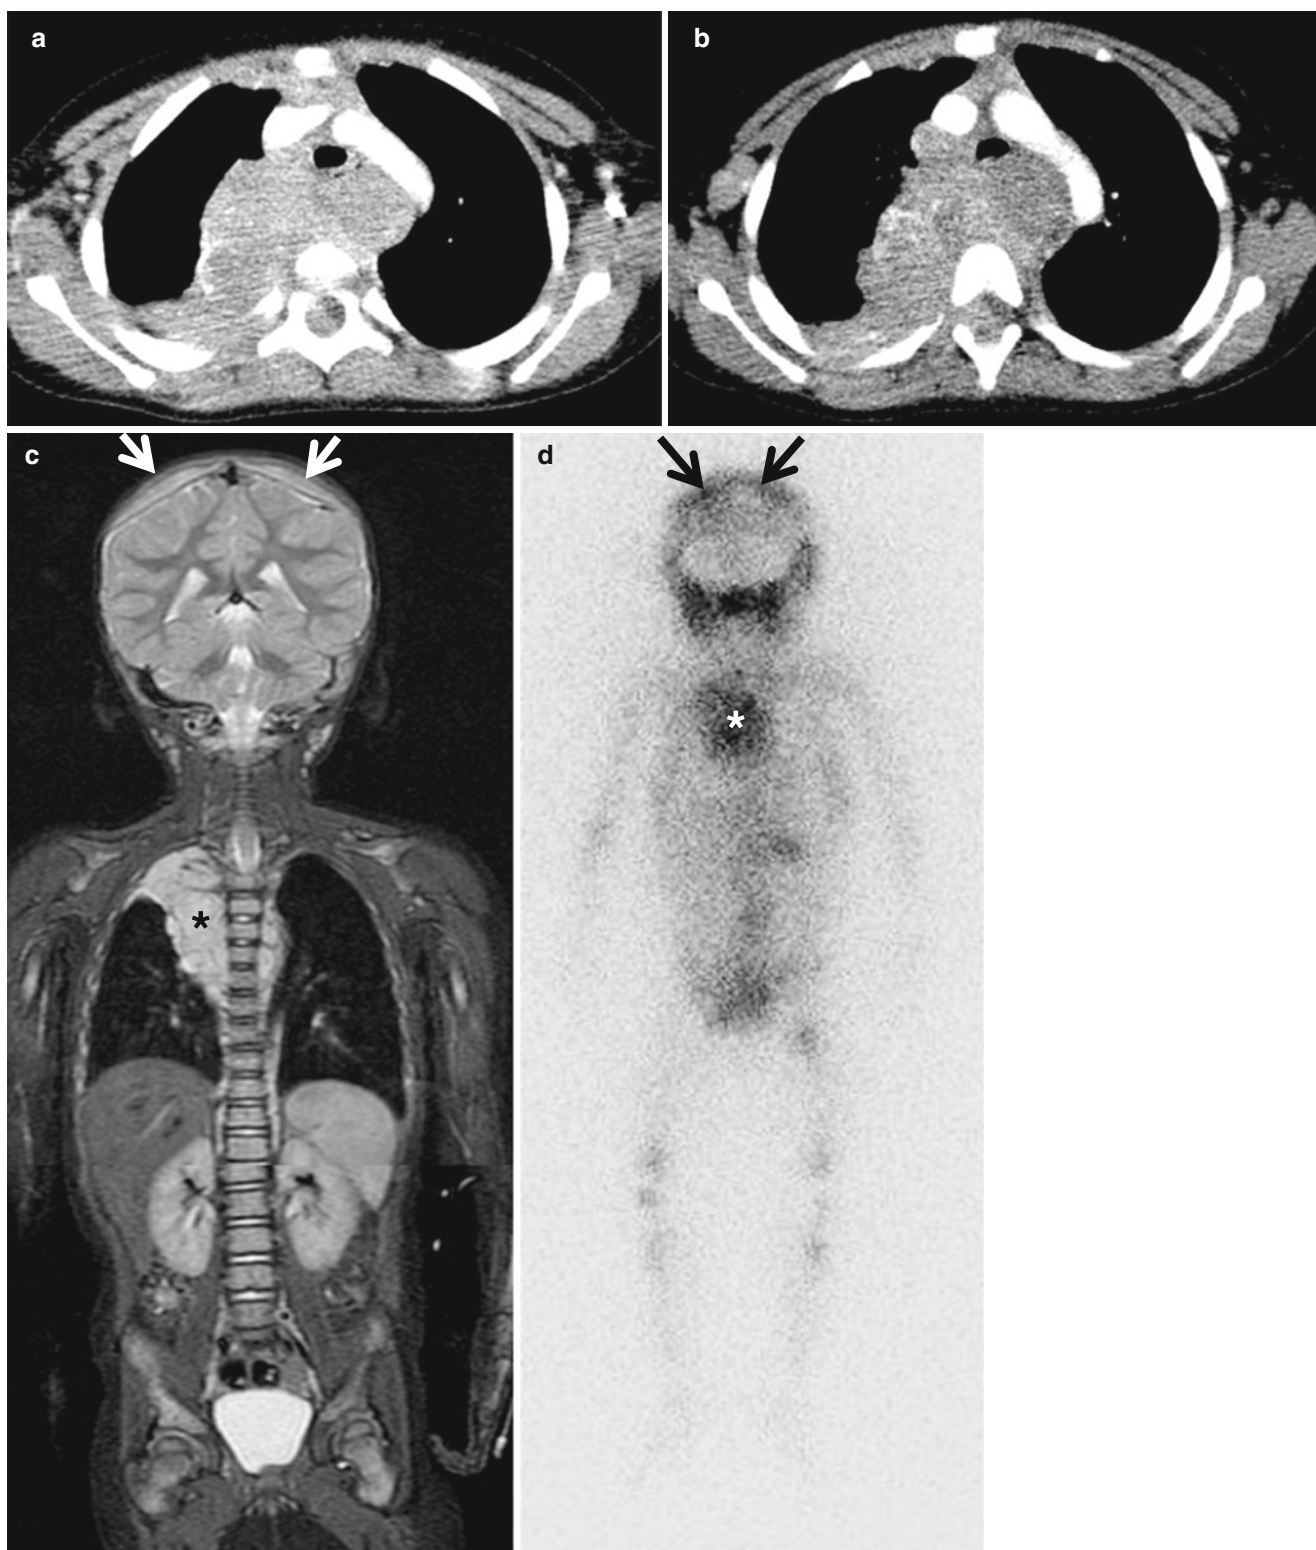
Neuroblastoma in a 2-year-old girl. (a, b) Contrast-enhanced CT shows a large soft tissue mass crossing the midline, displacing the trachea anteriorly. Note intraspinal tumor extension. (c) Coronal STIR image of the whole-body MRI demonstrates lobulated mediastinal mass (*asterisk*). Note associated dural thickening (*arrows*)
